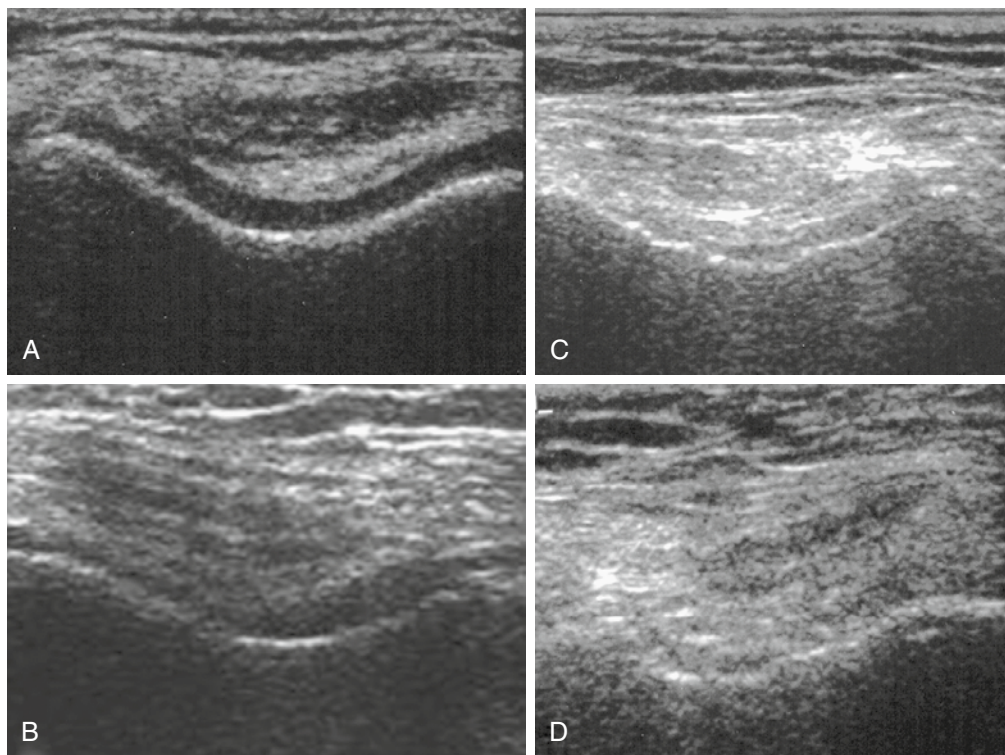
Anterior transverse scans in the suprapatellar area reveal the femoral condylar hyaline cartilage in a patient with osteoarthritis. A-D, The 10-MHz ultrasound images demonstrate progression of cartilage lesions, represented by blurring and irregularities of the superficial and deep interfaces with loss of their normal sharpness; changes in the echogenicity, with typical loss of homogeneity and transparency; and progressive thinning of the cartilage up to complete absence of the cartilaginous layer due to cartilage breakdown and bony denudation.
